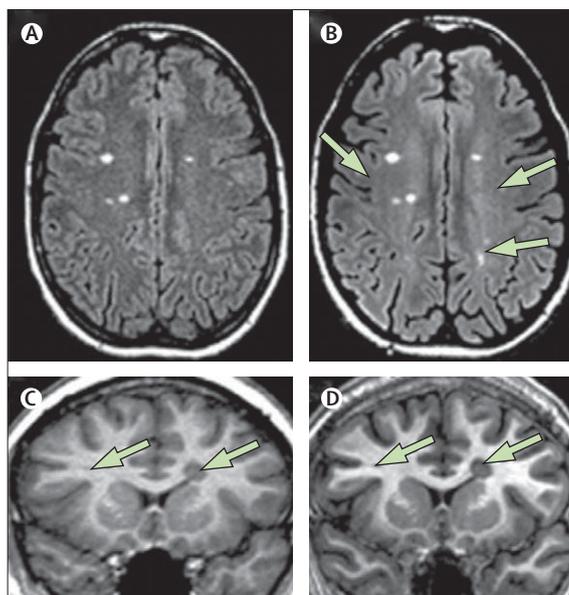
Comparison of 1.5 T and 3.0 T MRI in two patients with MS (A) 1.5 T and (B) 3.0 T MRI scans from a 48-year-old woman with secondary progressive MS, and (C) 1.5 T and (D) 3.0 T MRI scans from a 21 year-old man with relapsing-remitting MS are shown. (A) 1.5 T axial fast fluid inversion recovery (FLAIR) and (C) coronal spoiled gradient images of the brain, and 3.0 T images (B, D) of the same regions with equivalent pulse sequences on each patient display the improved sensitivity in lesion-detecting capabilities (arrows) and tissue resolution (tissue-CSF and grey-white matter differentiation) of the 3.0 T scanner. Reproduced with permission from Elsevier.¹¹
